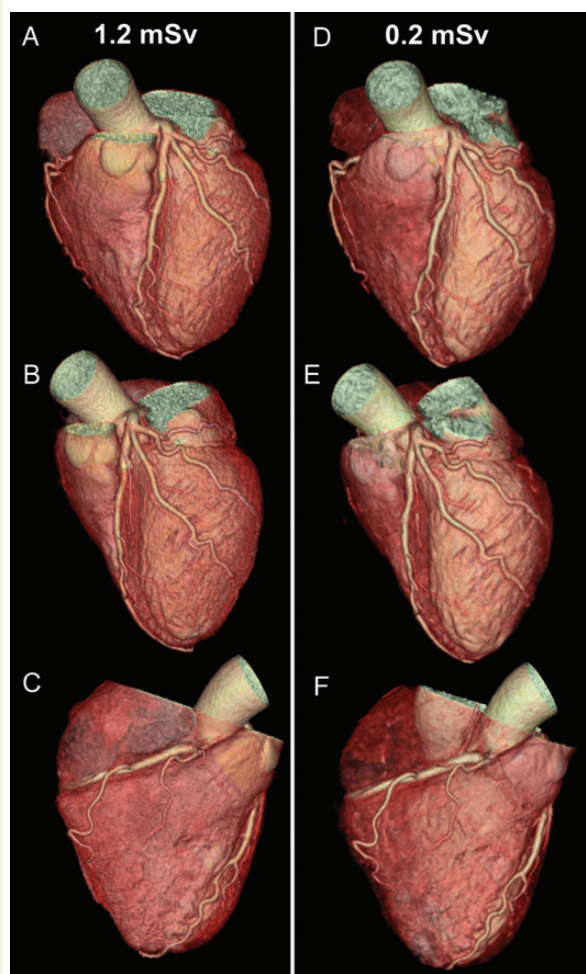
Three-dimensional volume rendered images from standard (A–C) and ultra-low-dose (D–F) coronary computed tomography angiography of the same patient acquired with 1.2 and 0.2 mSv.
